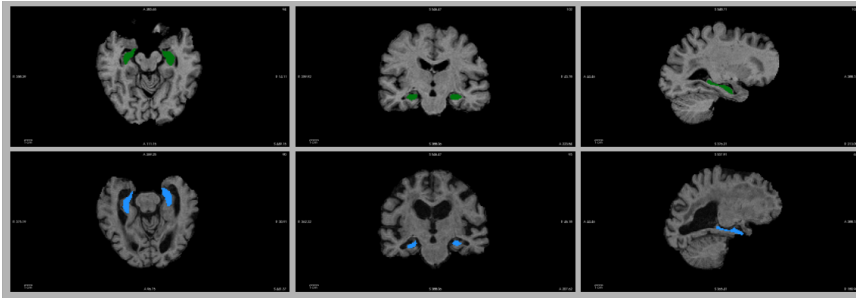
MRI brain scan of a female MCI patient (ID: 023-s-0887). The skull has been digitally removed and the hippocampus volume has been isolated using the FSL library. The top row has images from the baseline scan (aged 74), whereas the bottom row includes the latest recorded scan (aged 81). From left to right, the figure shows the axial, coronal, and sagittal views of the brain, where hippocampus regions are highlighted in green and blue. (In this paper, brain images are presented using FreeView application of FreeSurfer [40].)
